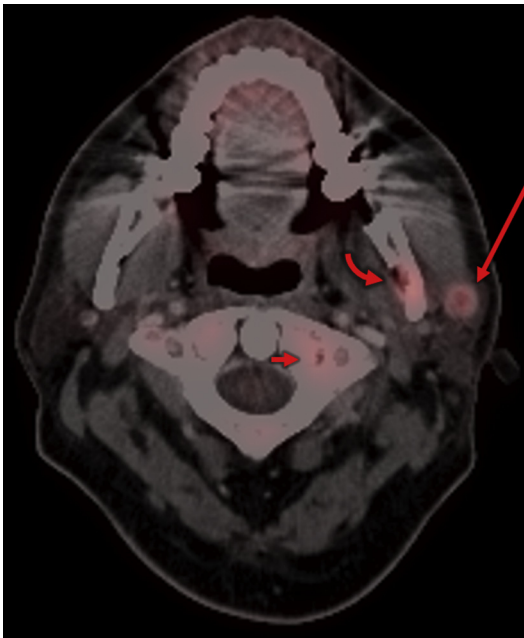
Parotid glands have multiple lymph nodes; thus, metastatic disease can present with cheek swelling or facial numbness/pain as in this case. FDG-avid metastatic parotid nodule from breast cancer in a 72-year-old woman (*long arrow*). Note the adjacent involvement in the mandible, along the inferior alveolar nerve (*curved arrow*). Additional osseous lesions were also present (*short arrow*).
